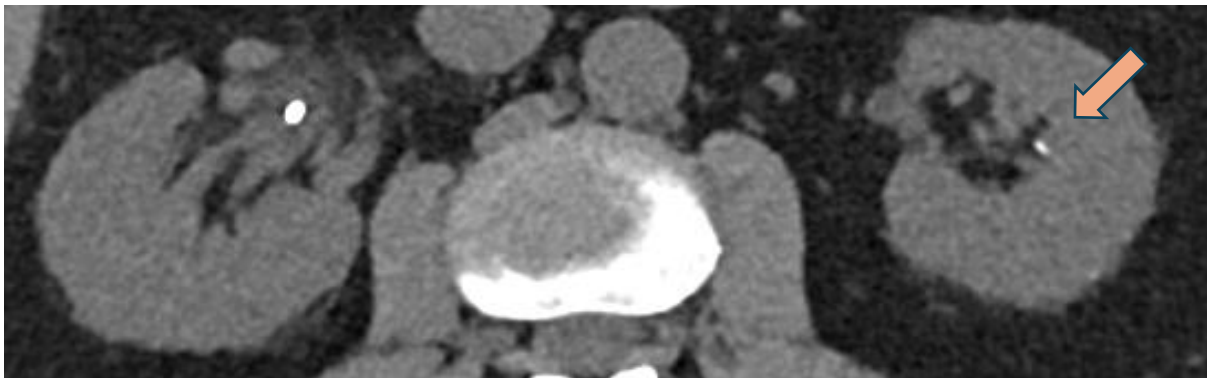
CT scan of May 2024 shows that the right pericatheter stone is no longer visible after treatment, and the left kidney stone has decreased in size.
